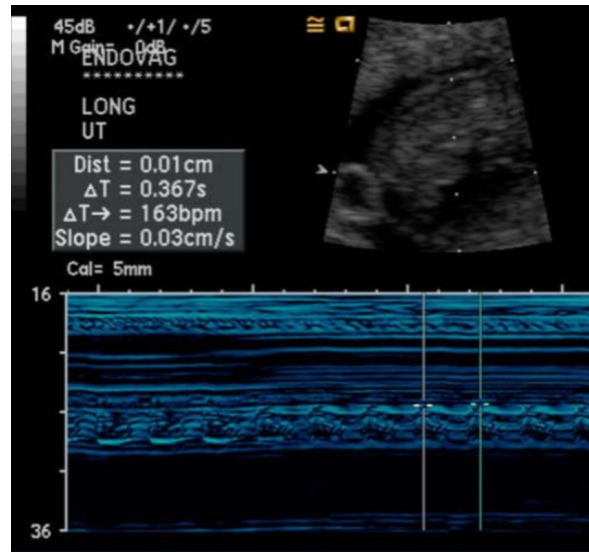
Follow-up transvaginal ultrasound demonstrates fetal cardiac activity at 163 BPM.
